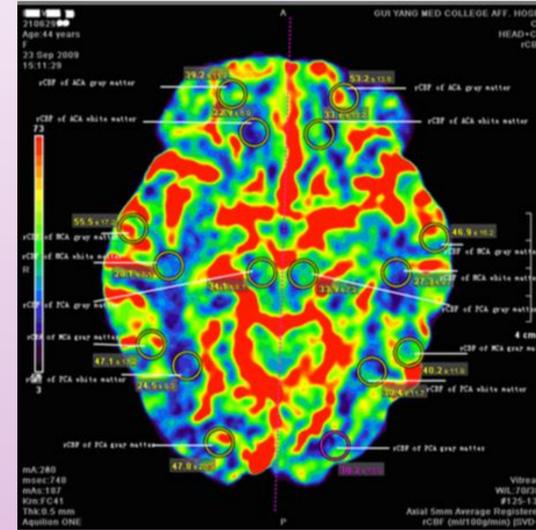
This image is a visual explanation of the results from the CT study on cerebral blood flow. The circles are the regions of interest. The middle cerebral artery regions show the values of regional cerebral blood flow in the left gray matter were lower than in the right. The posterior cerebral artery regions show the values of regional cerebral blood flow in the left gray matter were lower than the right.⁸
